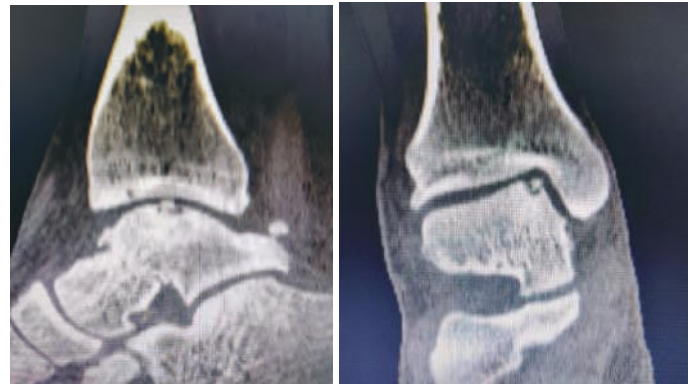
CT images of the patient showing the osteochondral lesion of medial talar dome with associated loose bodies in the ankle joint
